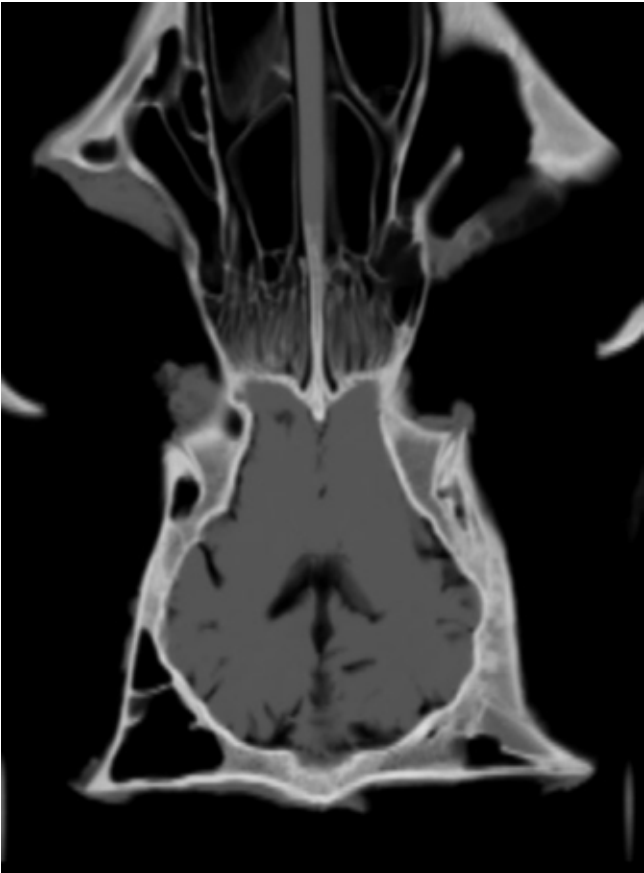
This figure shows an axial CT scan of the brain. The image was transferred from computer to projector and projected over subjects during entry to the frontal horn of lateral ventricle.
